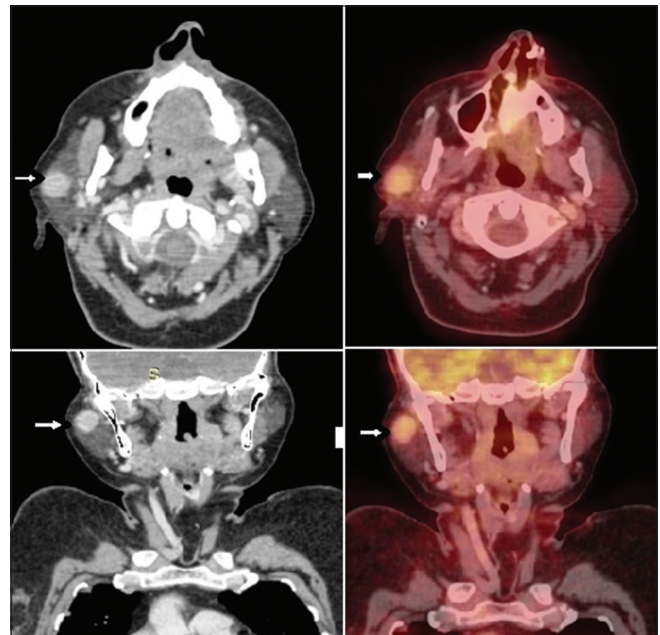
Contrast-enhanced computed tomography and fused 18F-fluorodeoxyglucose positron emission tomography/computed tomography axial and coronal sections show a well-defined nodular lesion measuring 1.8 cm × 1.7 cm × 1.6 cm in the right parotid gland showing good postcontrast enhancement and mild fluorodeoxyglucose avidity
